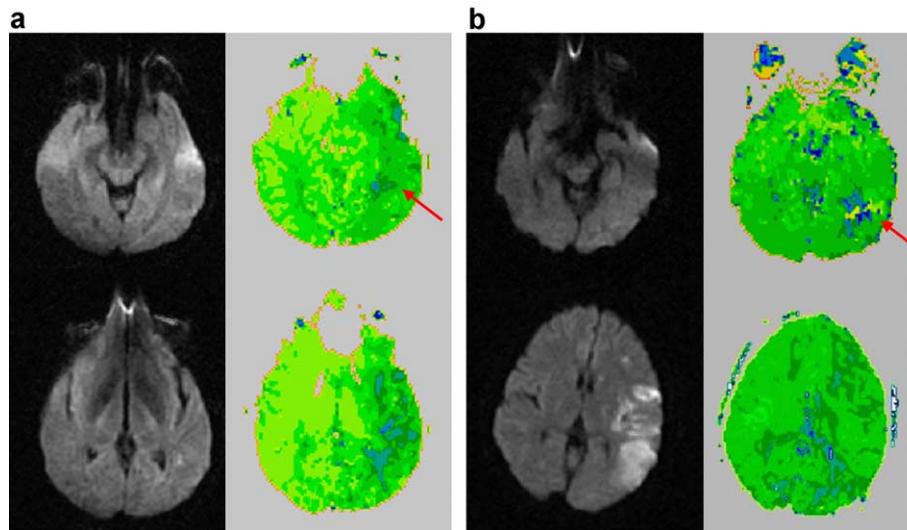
DWI (left) and PWI (right) scans of two patients (panels a and b) with hypoperfusion or infarct including VWFA, with normal written word comprehension and lexical decision but impaired naming. Hypoperfused areas appear blue. The red arrow points to VWFA. All figures in this paper show the left half of the brain on the right (neuroradiological convention).
